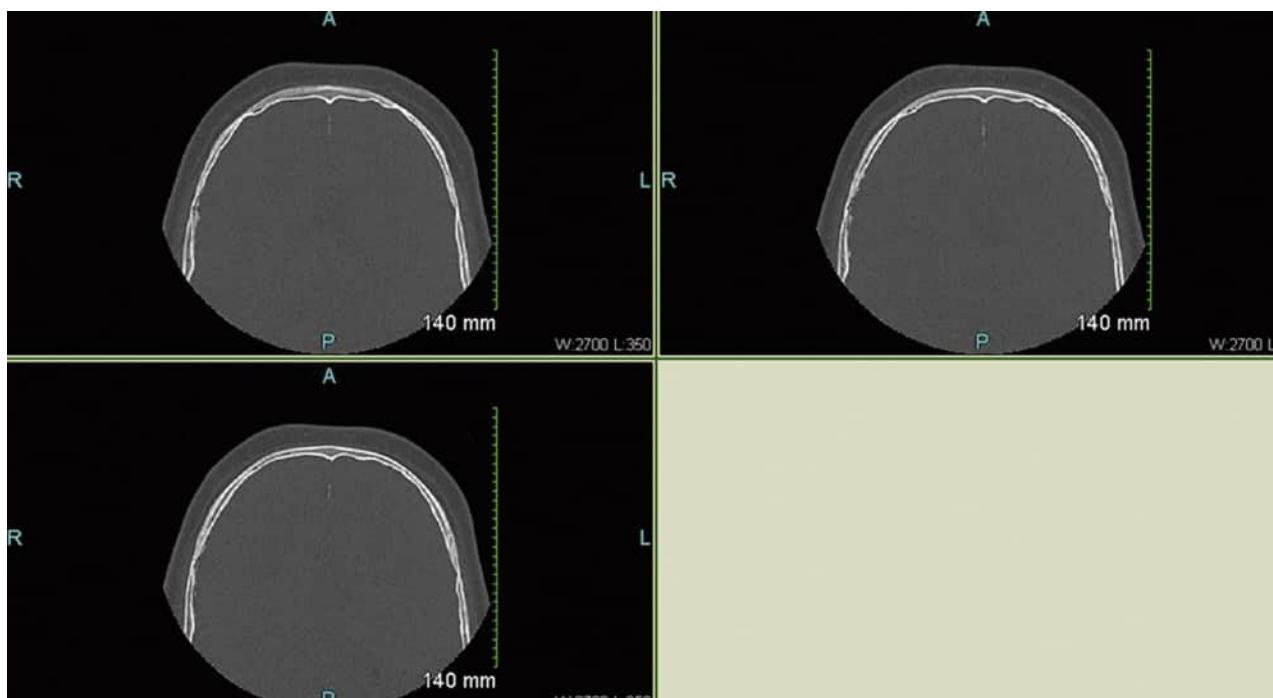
CBCT, axial view (same patient Fig. 5.33). Calcification of the falx cerebri.
